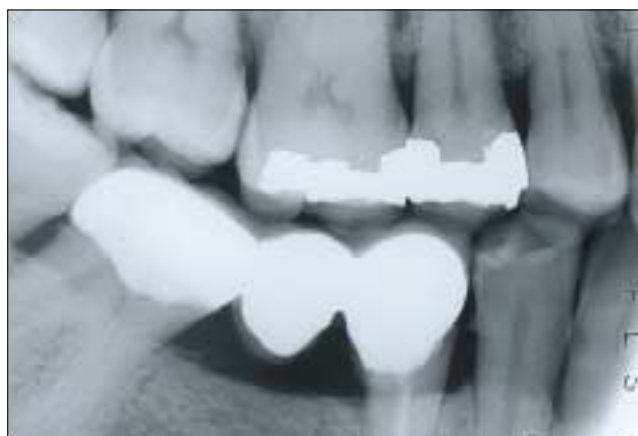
Radiographic image of the fixed partial denture just over 7 years after initial recementation with a dentin-bonded resin cement. The recementation helped to maintain the integrity of the dental arch over the years and preserved the abutment teeth from caries.
